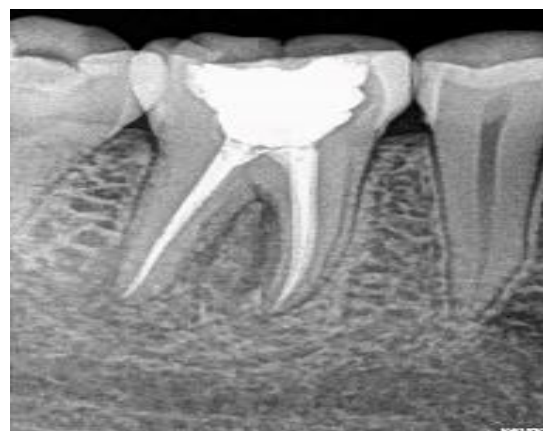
radiograph at 12 months follow-up
